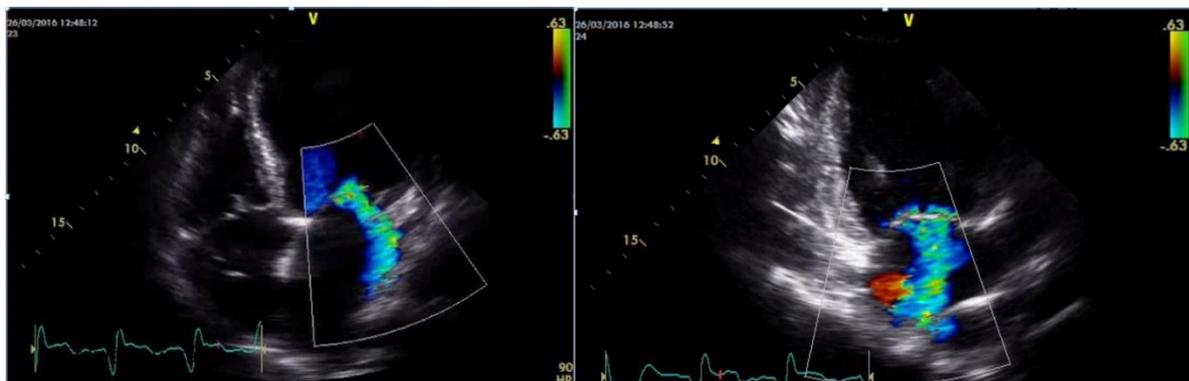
2D Transthoracic echocardiography apical 4-chamber and apical 2-chamber views during VVI pacing. Dilated left ventricle. Severe mitral regurgitation
